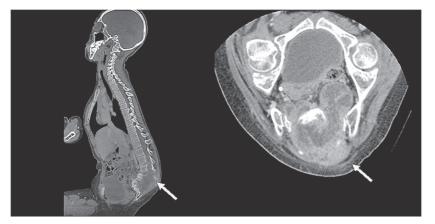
Computed tomography with contrast revealed a solid sacral mass $12 \times 8 \times 8$ cm in size, with a well-defined contour, high-density wall, and scalloping of the bone from L4 to the sacrum.
